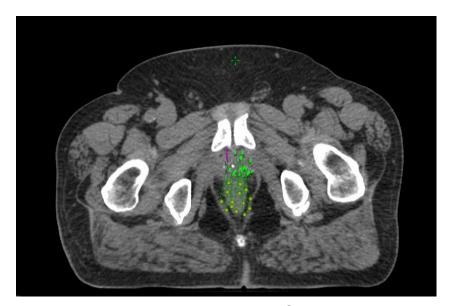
catheter reconstruction on CT
